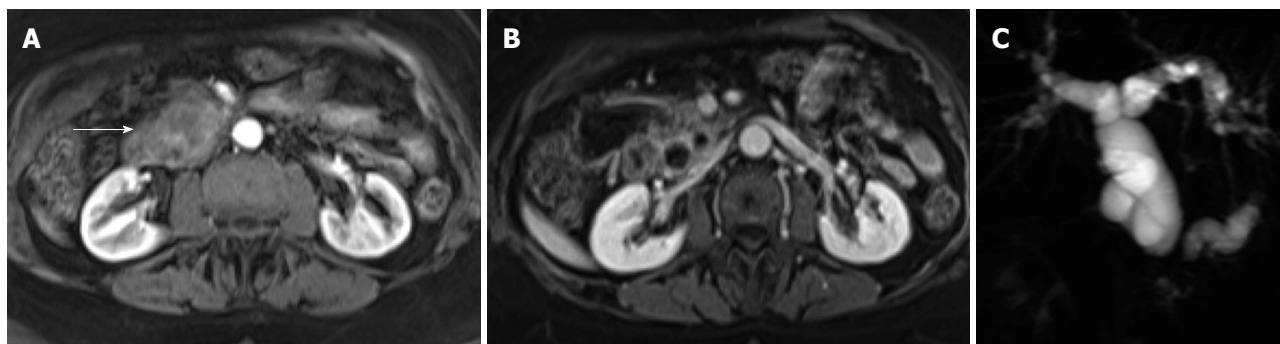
Pancreatic ductal adenocarcinoma. Axial post-gadolinium fat-suppressed T1-weighted images obtained in the arterial phase (A) and interstitial phase (B) image, and coronal maximum intensity projection image of MRCP (C). There is a hypovascular tumor arising in the pancreatic head (arrow, A) that obstructs the common bile duct and pancreatic duct (double duct sign). This sign is well depicted in the MRCP images (C). MRCP: Magnetic resonance cholangiopancreatography.
